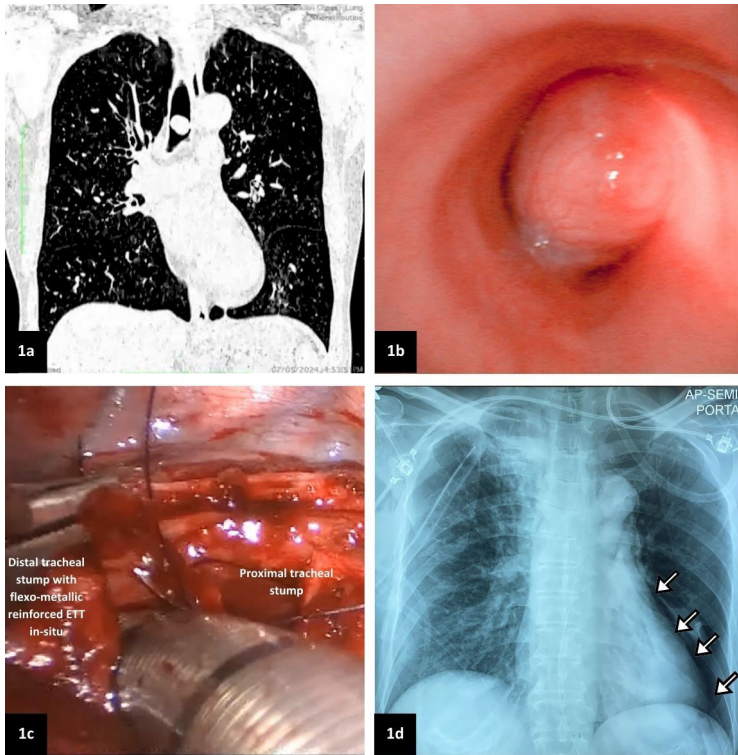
(a) Computed tomography image showing a pedunculated tracheal mass above the carina. (b) Bronchoscopic view of the tracheal mass obstructing the trachea above the carina. (c) Thoracoscopic view of the distal tracheal stump intubated with an flexo-metallic reinforced endotracheal tube (ETT) during cross-field ventilation. (d) Postoperative chest X-ray revealing a left pneumothorax (white arrow). The right chest tube is *in situ*.
